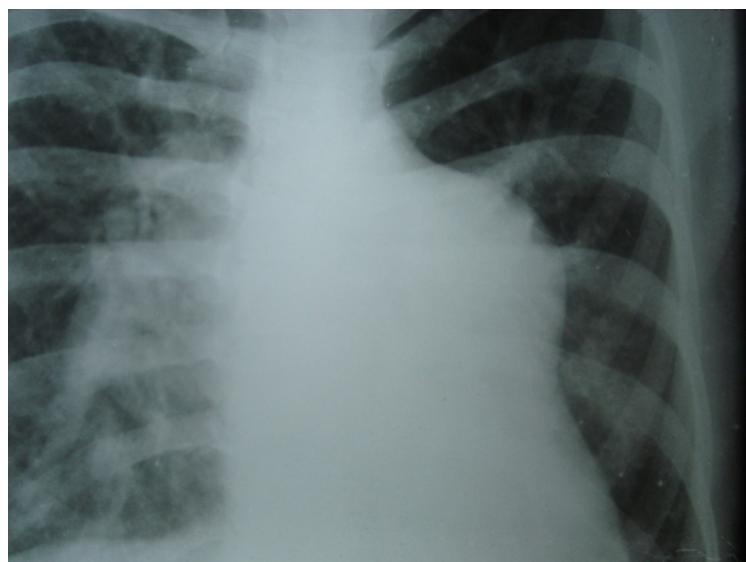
Chest X-ray showing cardiomegaly with increased pulmonary vascularity along with a prominent convexity on left margin of cardiac shadow, suggestive of rudimentary outlet chamber.
